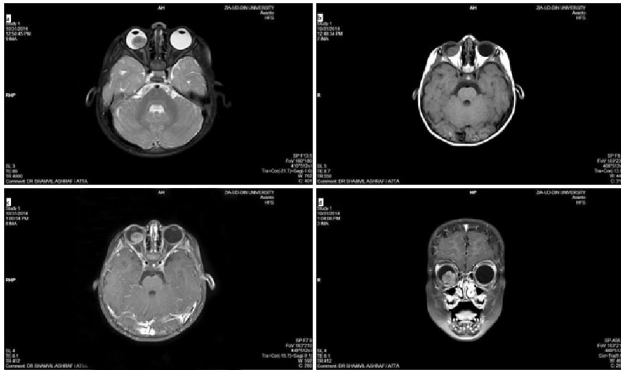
MRI brain and orbit of 2 years old female patient a. T2W axial b. T1W axial c & d. T1W axial and sagittal post gadolinium images. There is a polypoid inhomogeneously enhancing mass occupying the posterior chamber right globe. The central area is low intensity on all sequences represent tumor calcification. Normal both optic nerves and left globe.
